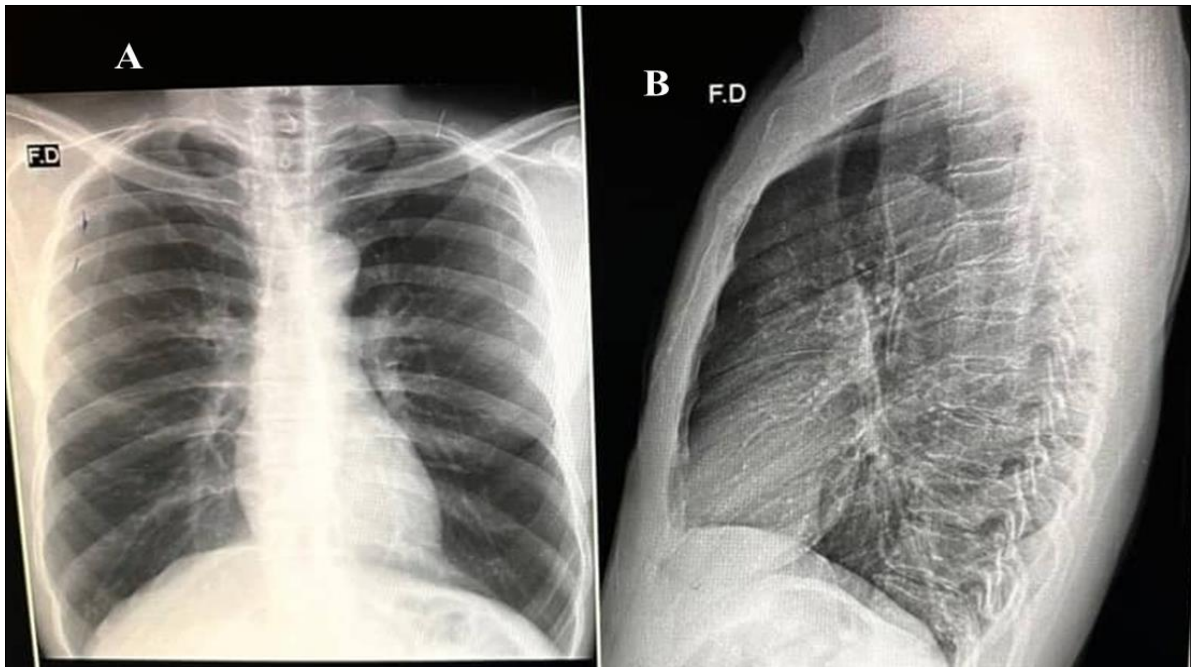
Normal frontal (A) and lateral (B) chest radiograph
